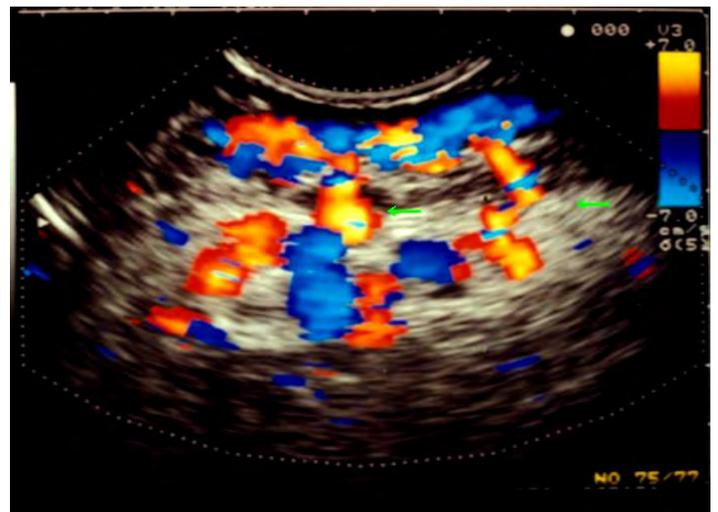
Endoscopic color Doppler ultrasonography show inflow from the paraesophageal veins to the esophageal varices (arrow).
